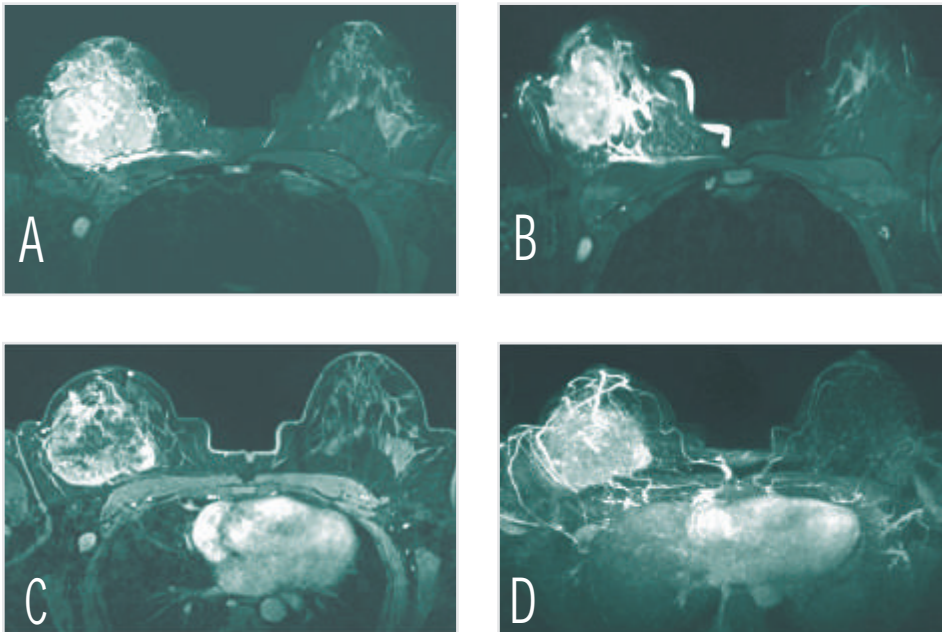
Pre chemotherapy MR images of a 44 year old female patient
